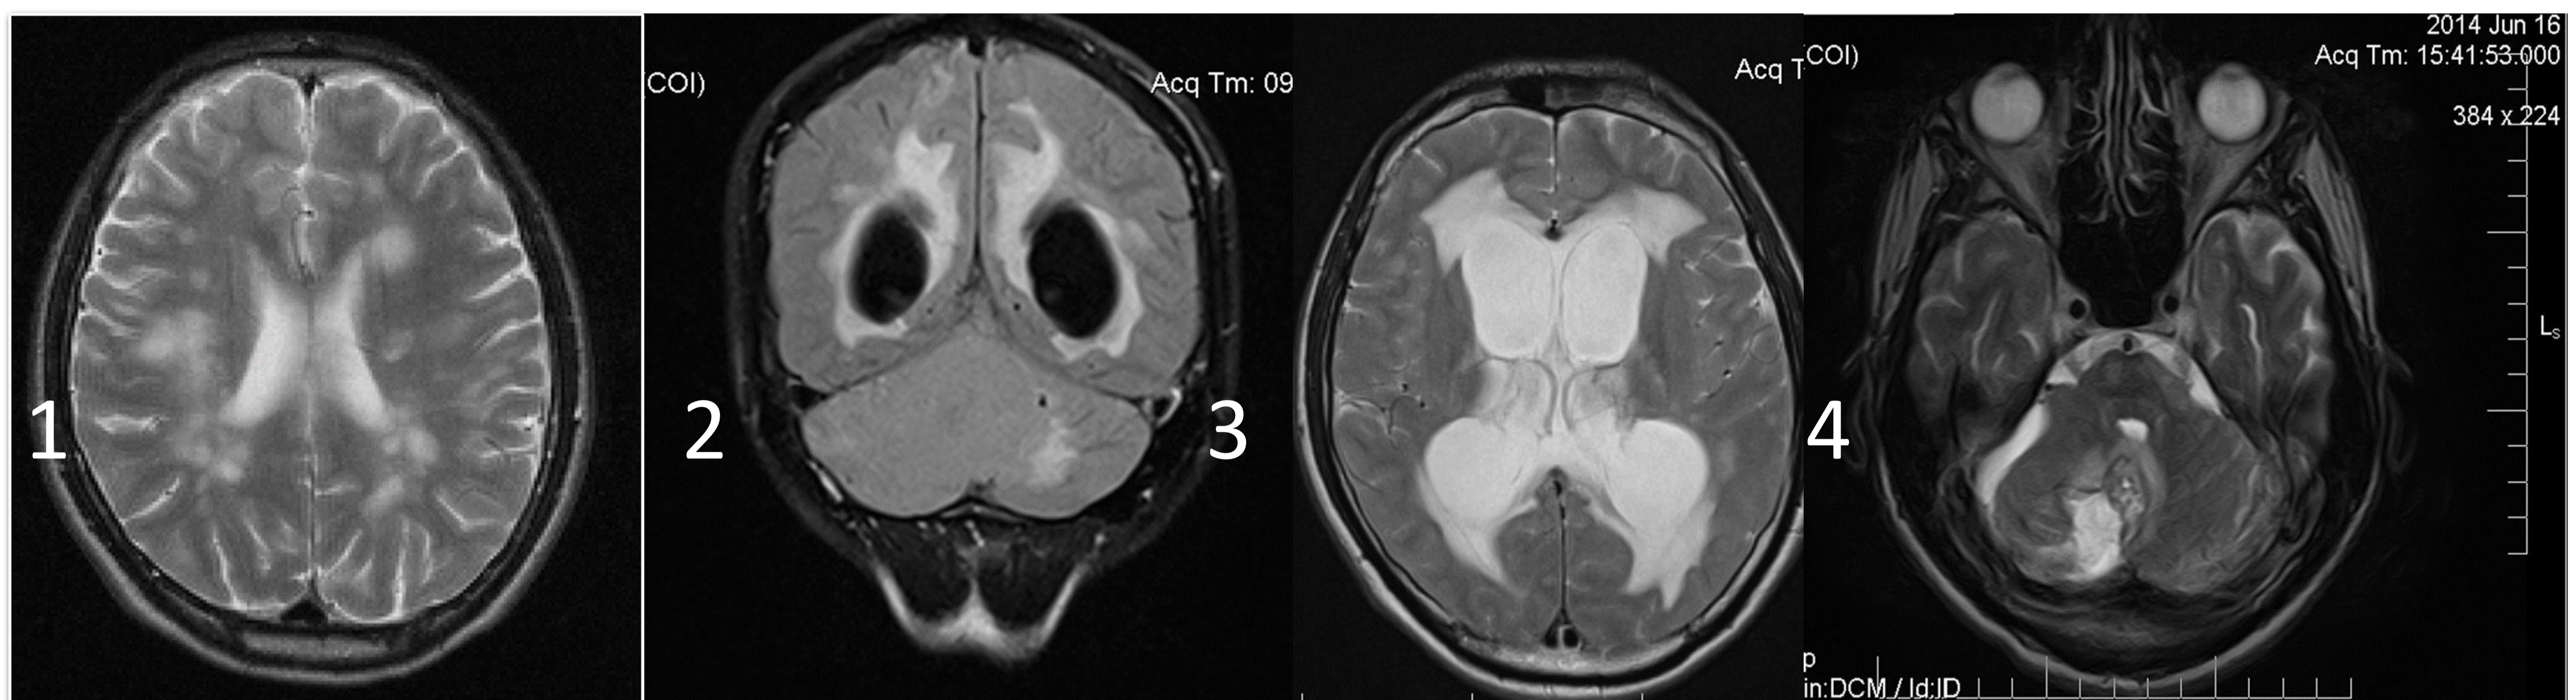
Brain MRI one year after initiation of DMT treatment reveals multiple ovoid demyelinating lesions adjacent to the ventricles(1); brain exam 6 years later developed a tumor in the posterior fossa, vermis and right cerebellar hemisphere, which compresses the IV ventricle and determines important mass effect and secondary hydrocephalus(2,3); imagistic control after surgery (4).
